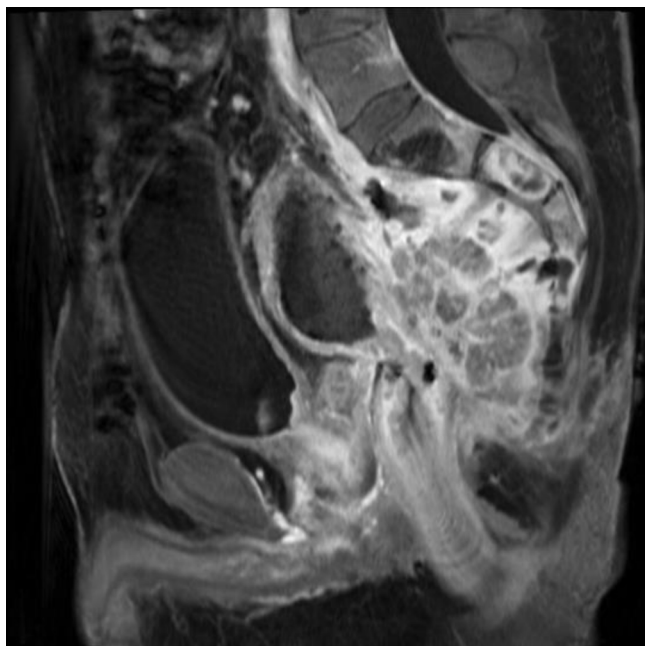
Sagittal CT scan view of recurrent rectal cancer which presented as a retroperitoneal perforation forming a recto-cutaneous fistula through the sacrum with extensive adjacent soft tissue infection and necrosis.
